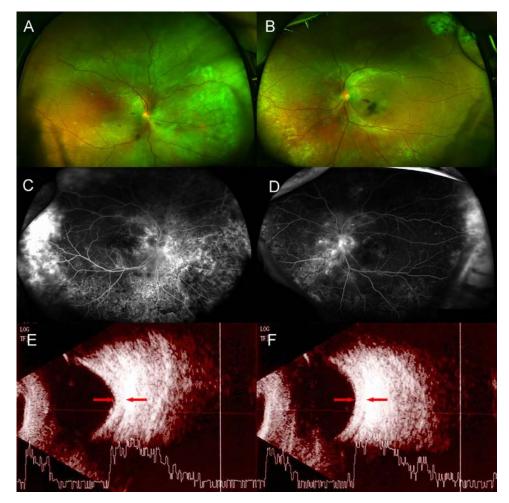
Ultrawide-field fundus photography, ultrawide-field fluorescein angiography, and B-scan ultrasonography at initial presentation. (A, B) Fundus photography showing serous retinal detachment with pigmentary changes. (C, D) Fluorescein angiography reveals multiple punctate leakage in both eyes and pooling of dye in the areas of serous retinal detachment in the right eye. (E, F) B-scan ultrasonography shows the thickened sclera in both eyes.
